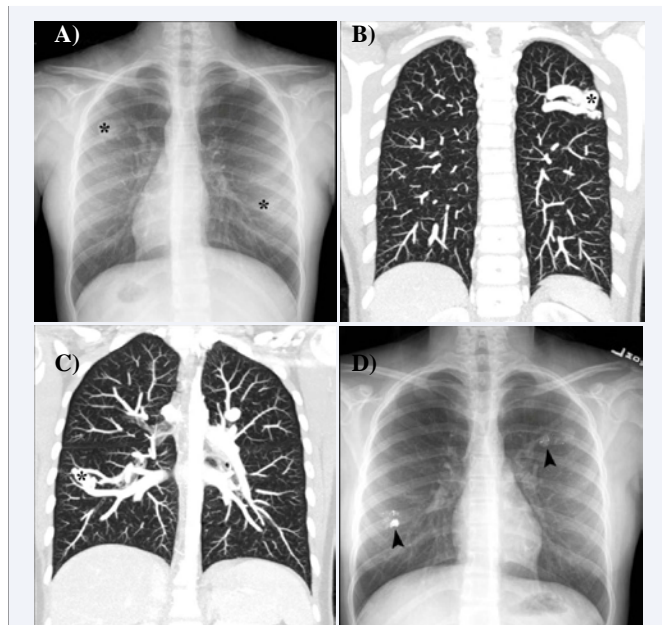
Imaging of Pulmonary Arteriovenous Malformation (PAVM) A.  FIGURE 1A IS UPSIDE DOWN. B-C. Chest CT with intravenous contrast reconstructed as coronal Maximal Intensity Projection images. PAVMs (*mark) with enlarged feeding pulmonary artery and draining pulmonary vein. D. Chest X-ray after transcatheter embolotherapy. Endovascular plugs and coils within pulmonary arteries feeding PAVMs (arrowheads).
